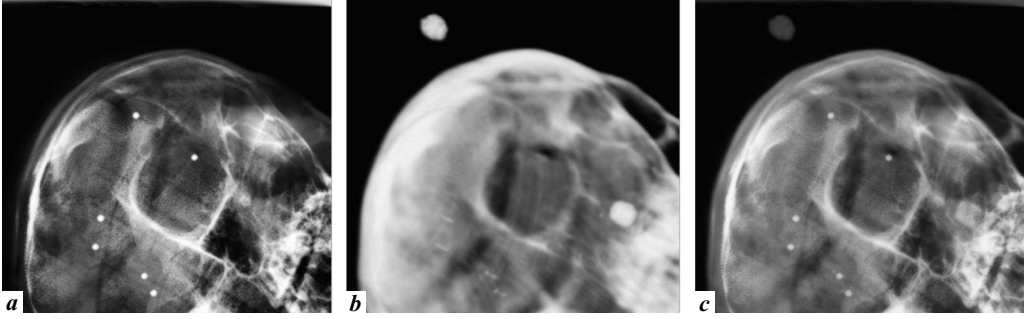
6D fusion of X-ray images with corresponding DRR. *a* X-ray image, *(b)* DRR, and *(c)* fusion (mixed) image of *(a)* and *(b)*.
